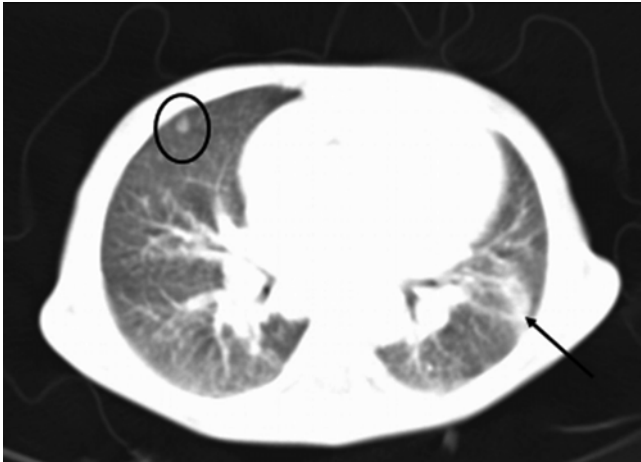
Transverse CT image of patient with nephroblastoma and HIV infection. Note tuberculosis (*arrow*) and intra-pulmonary lymph node (*circled*) showing HIV lymphadenitis on biopsy
